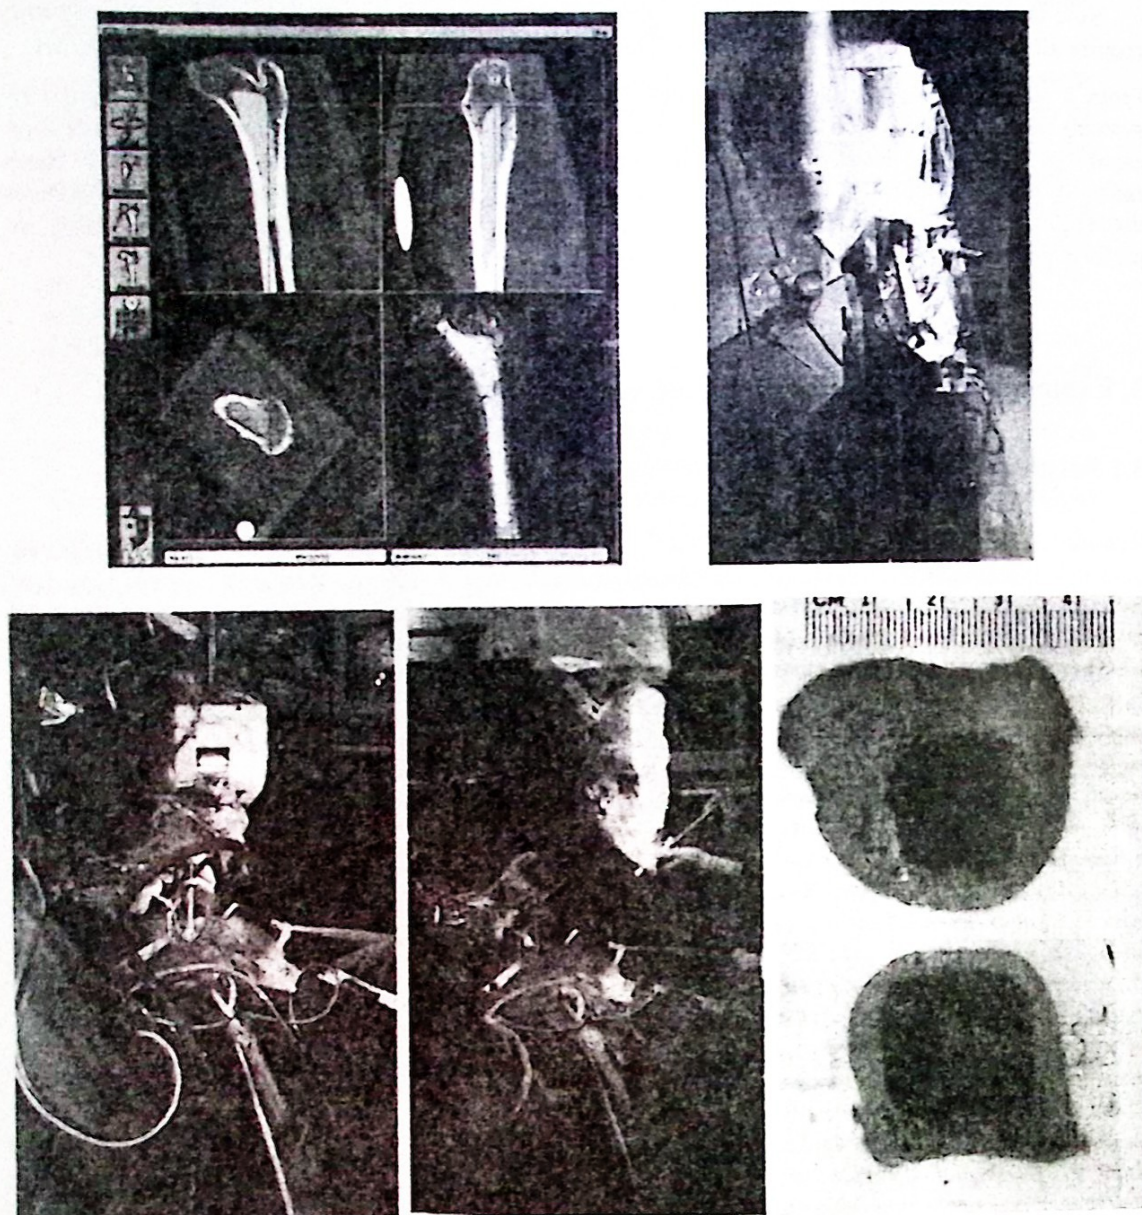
The ROBODOC system. The top left figure shows a screen of ORTHODOC, the preoperative planning module. Three windows show orthogonal cross sections of the CT and one shows a three-dimensional reconstruction of the femur. The yellow shape is the implant, which is chosen and positioned by the surgeon before the surgery. The top right figure shows the six-axis robot covered by a sterile protection drape. The machining tool (center) is inclined to provide better access to the patient trochanter. In the bottom left and center, the ROBODOC system in action: the surgeon attaching the milling tool to the robot after patient preparation (left), and in the robot milling the femoral canal (center). The bottom left image shows cross sections of a manually broached femur (top) and a robotically machined femur (bottom), which has superior surface finish and fit.
